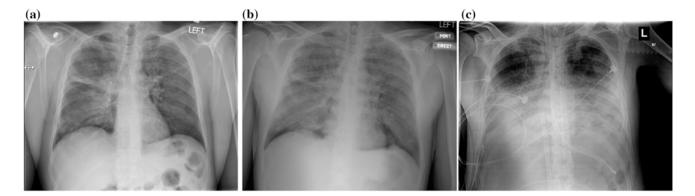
Serial chest radiographs from a the day of presentation to the emergency department, b prior to and c after ECMO initiation demonstrate progressive worsening bilateral pulmonary infiltrates
